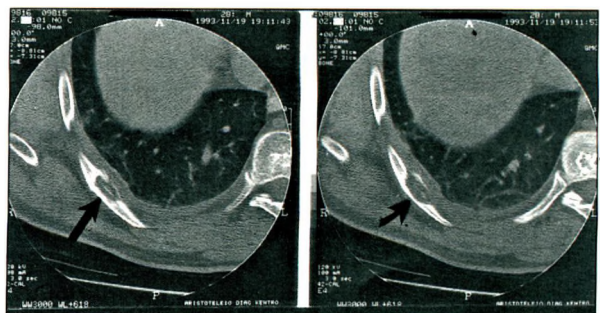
CT scan of the thorax demonstrates a lytic lesion of the anterior aspect of the right 9th rib (arrow).
